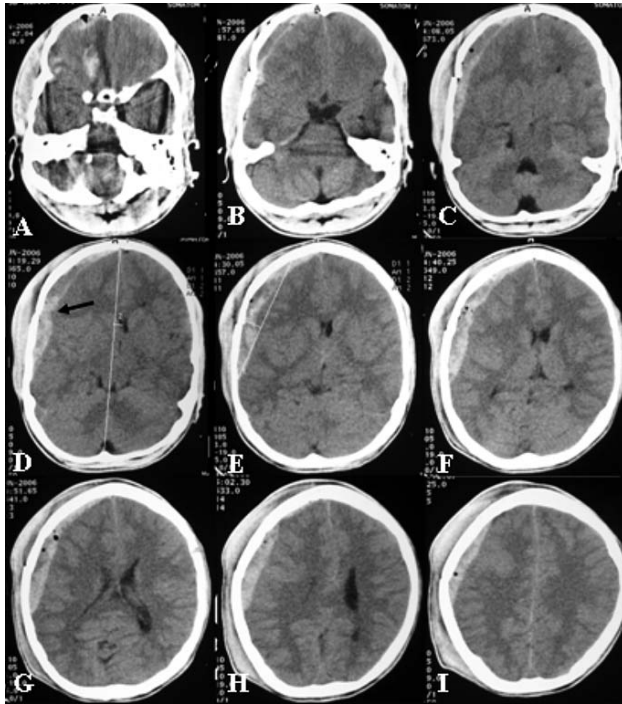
CT scan showing extensive hyperdense crescentic shaped hyperdense collection with areas of hypodensity along the right fronto-temporo-parietal convexity. Note that in panel A the lesion is biconvex with a speck of pneumocephalus, and in panel D the lesion appears separated at the suture line (black arrow). There is associated mass effect and midline shift, although the underlying parenchyma is normal with buckling effect.
